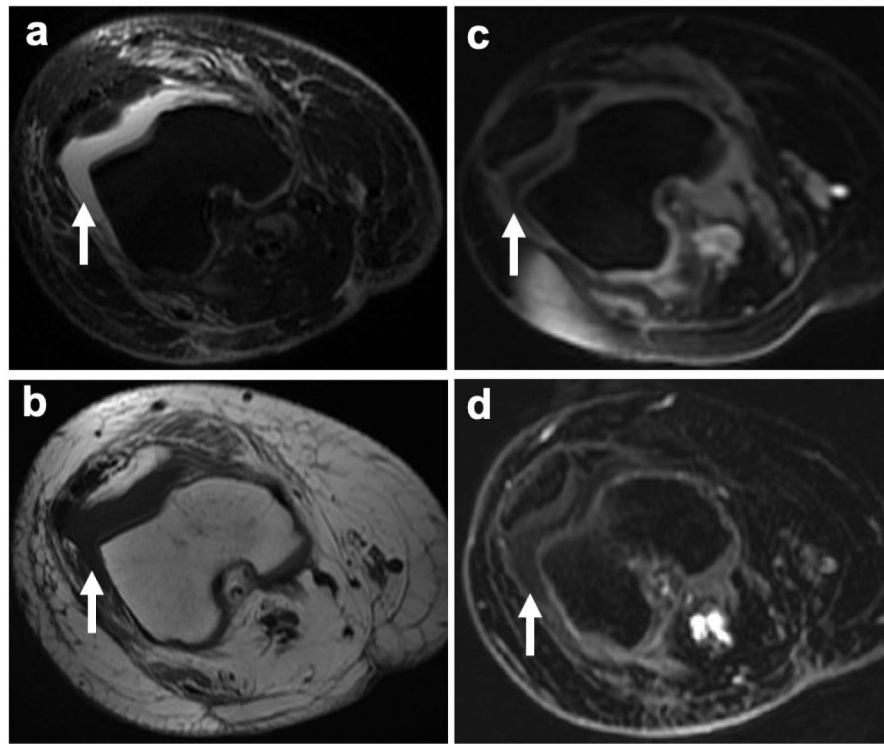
Knee joint effusion without T1-enhancement in a 24-year old female patient with recurrence of osteosarcoma in the right femur. a Axial PD-weighted FSE image shows a hyperintense knee joint effusion (arrow). b Corresponding pre-contrast axial T1-weighted FSE images demonstrates a hypointense joint effusion (arrow). c Post gadolinium and d 1 hour post ferumoxytol LAVA images show a hypointense knee joint effusion without T1-enhancement (arrows)
